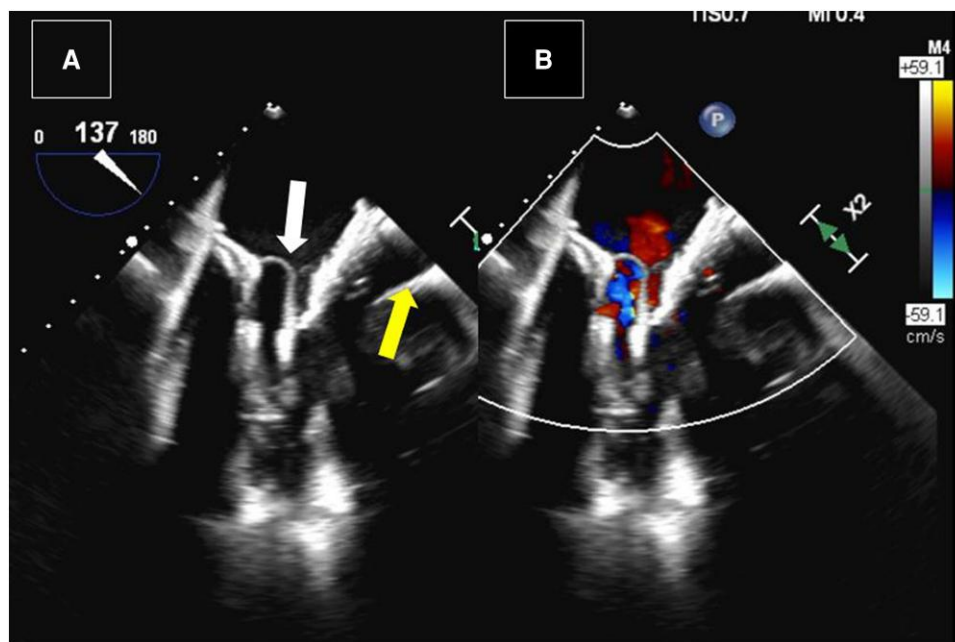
Transoesophageal echocardiography after the transcatheter mitral valve implantation showing a well-seated Tendyne valve (A, white arrow) without residual mitral regurgitation (B) on colour Doppler. A transcatheter aortic valve implant is also seen (yellow arrow).
